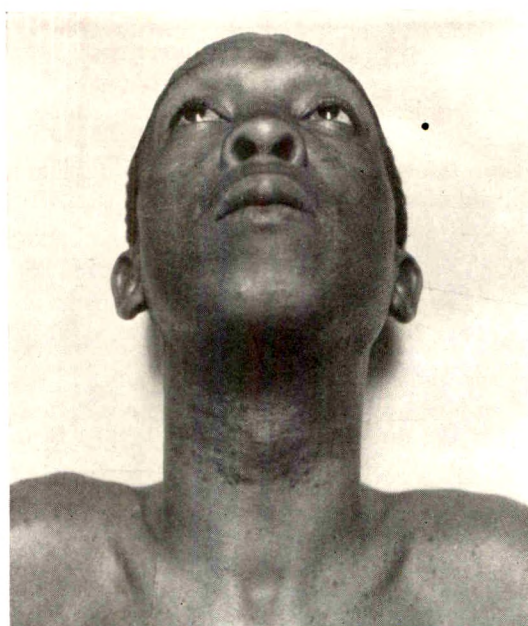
Same as Figure 6, following roentgen irradiation with fractional doses as practised in tuberculosis.
